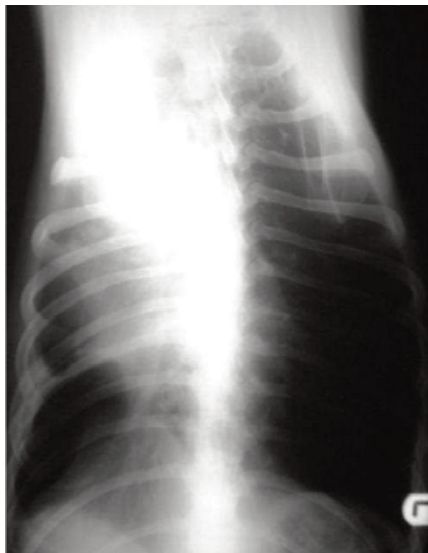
Ventrrodorsal thoracic radiograph taken 30 days after surgery revealed limited expansions of the right lung lobes and minimal right mediastinal shift, which was consistent with possible pleurodesis.
